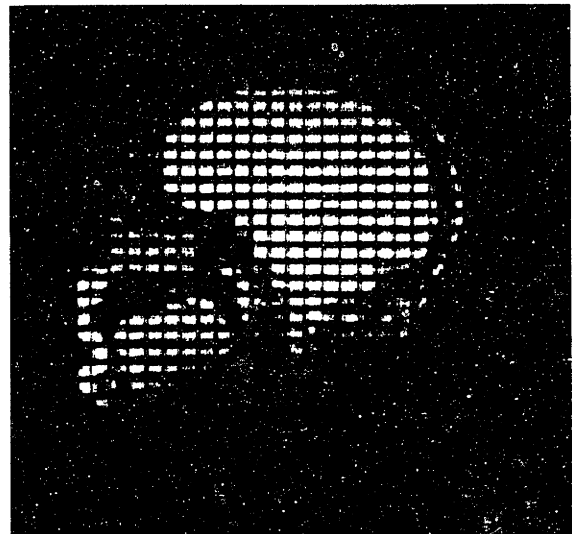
Tagging MRI with undeformed grid
